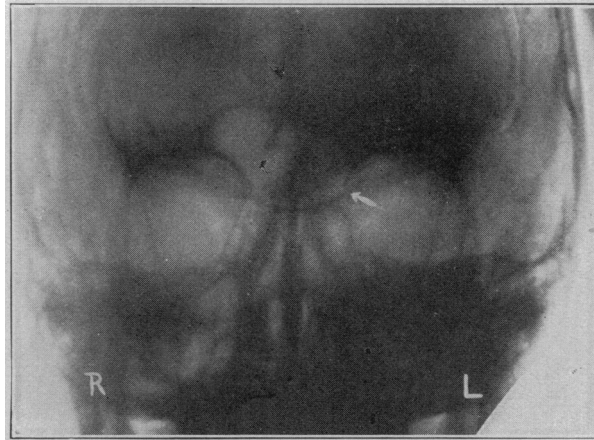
Roentgenogram taken Dec. 3, 1914, before the first operation, showing a small left frontal sinus filled with pus, and the dehiscence of bone (indicated by arrow) leading into orbit; left ethmoidal and maxillary sinuses also positive. On the right is shown a large frontal sinus partially divided by a septum, clearly free from pus; ethmoids and antrum negative. Six months later these were all full of pus, with a fistula leading into orbit; an exact counterpart of the condition on the left.
